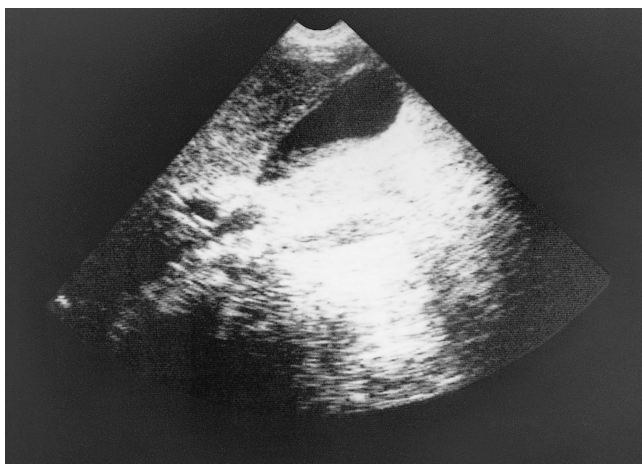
An abnormal abdominal ultrasound examination confirming the diagnosis of acute acalculous cholecystitis. When the image is compared with that in Figure 2, thickening of the gallbladder wall and intraluminal debris are obvious.
